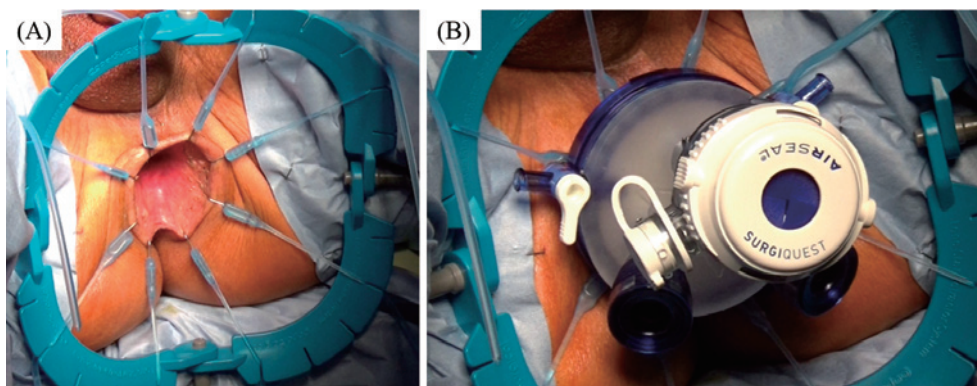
Installation with (A) Lone Star Self-Retaining Retractor (CooperSurgical, Inc., Trumbull, CT, USA) and (B) GelPOINT Path Transanal Access Platform (Applied Medical Resources Corp., Rancho Santa Margarita, CA, USA).
